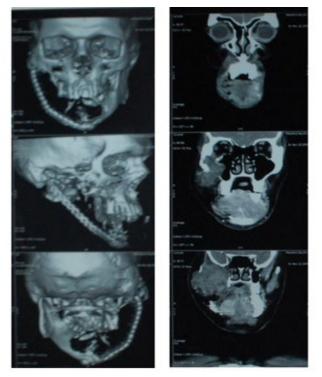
Computed tomographic scan shows bony destruction of left mandible crossing midline.
